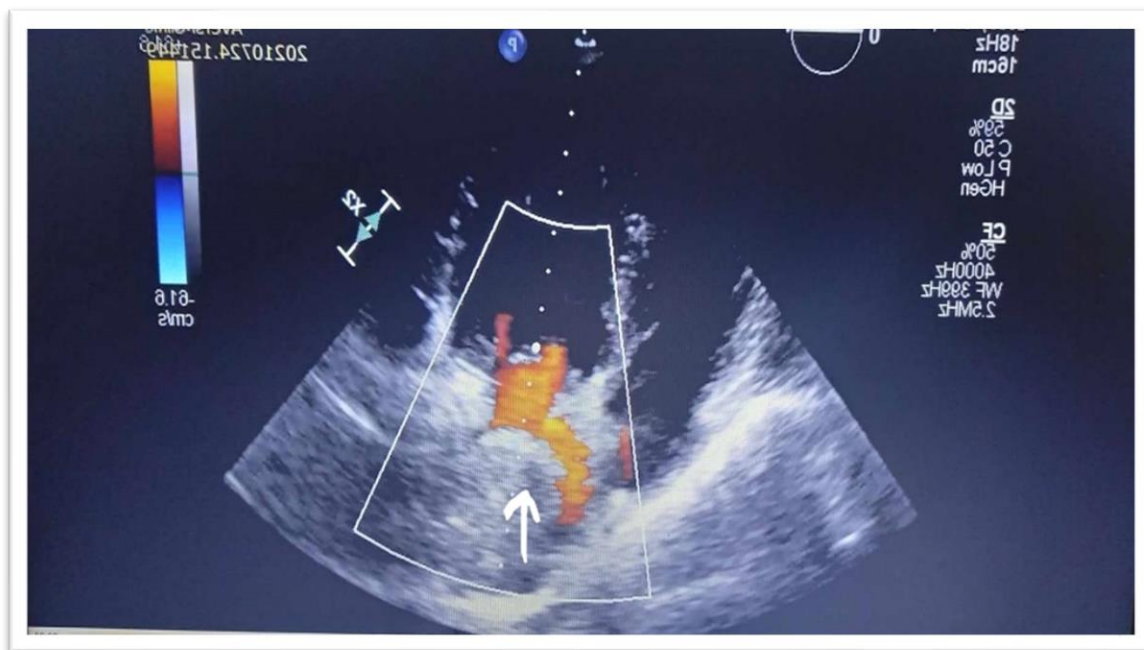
Apical 4-chamber view with color Doppler. Left atrial and pulmonary vein compression with extra cardiac structure (white arrow)
